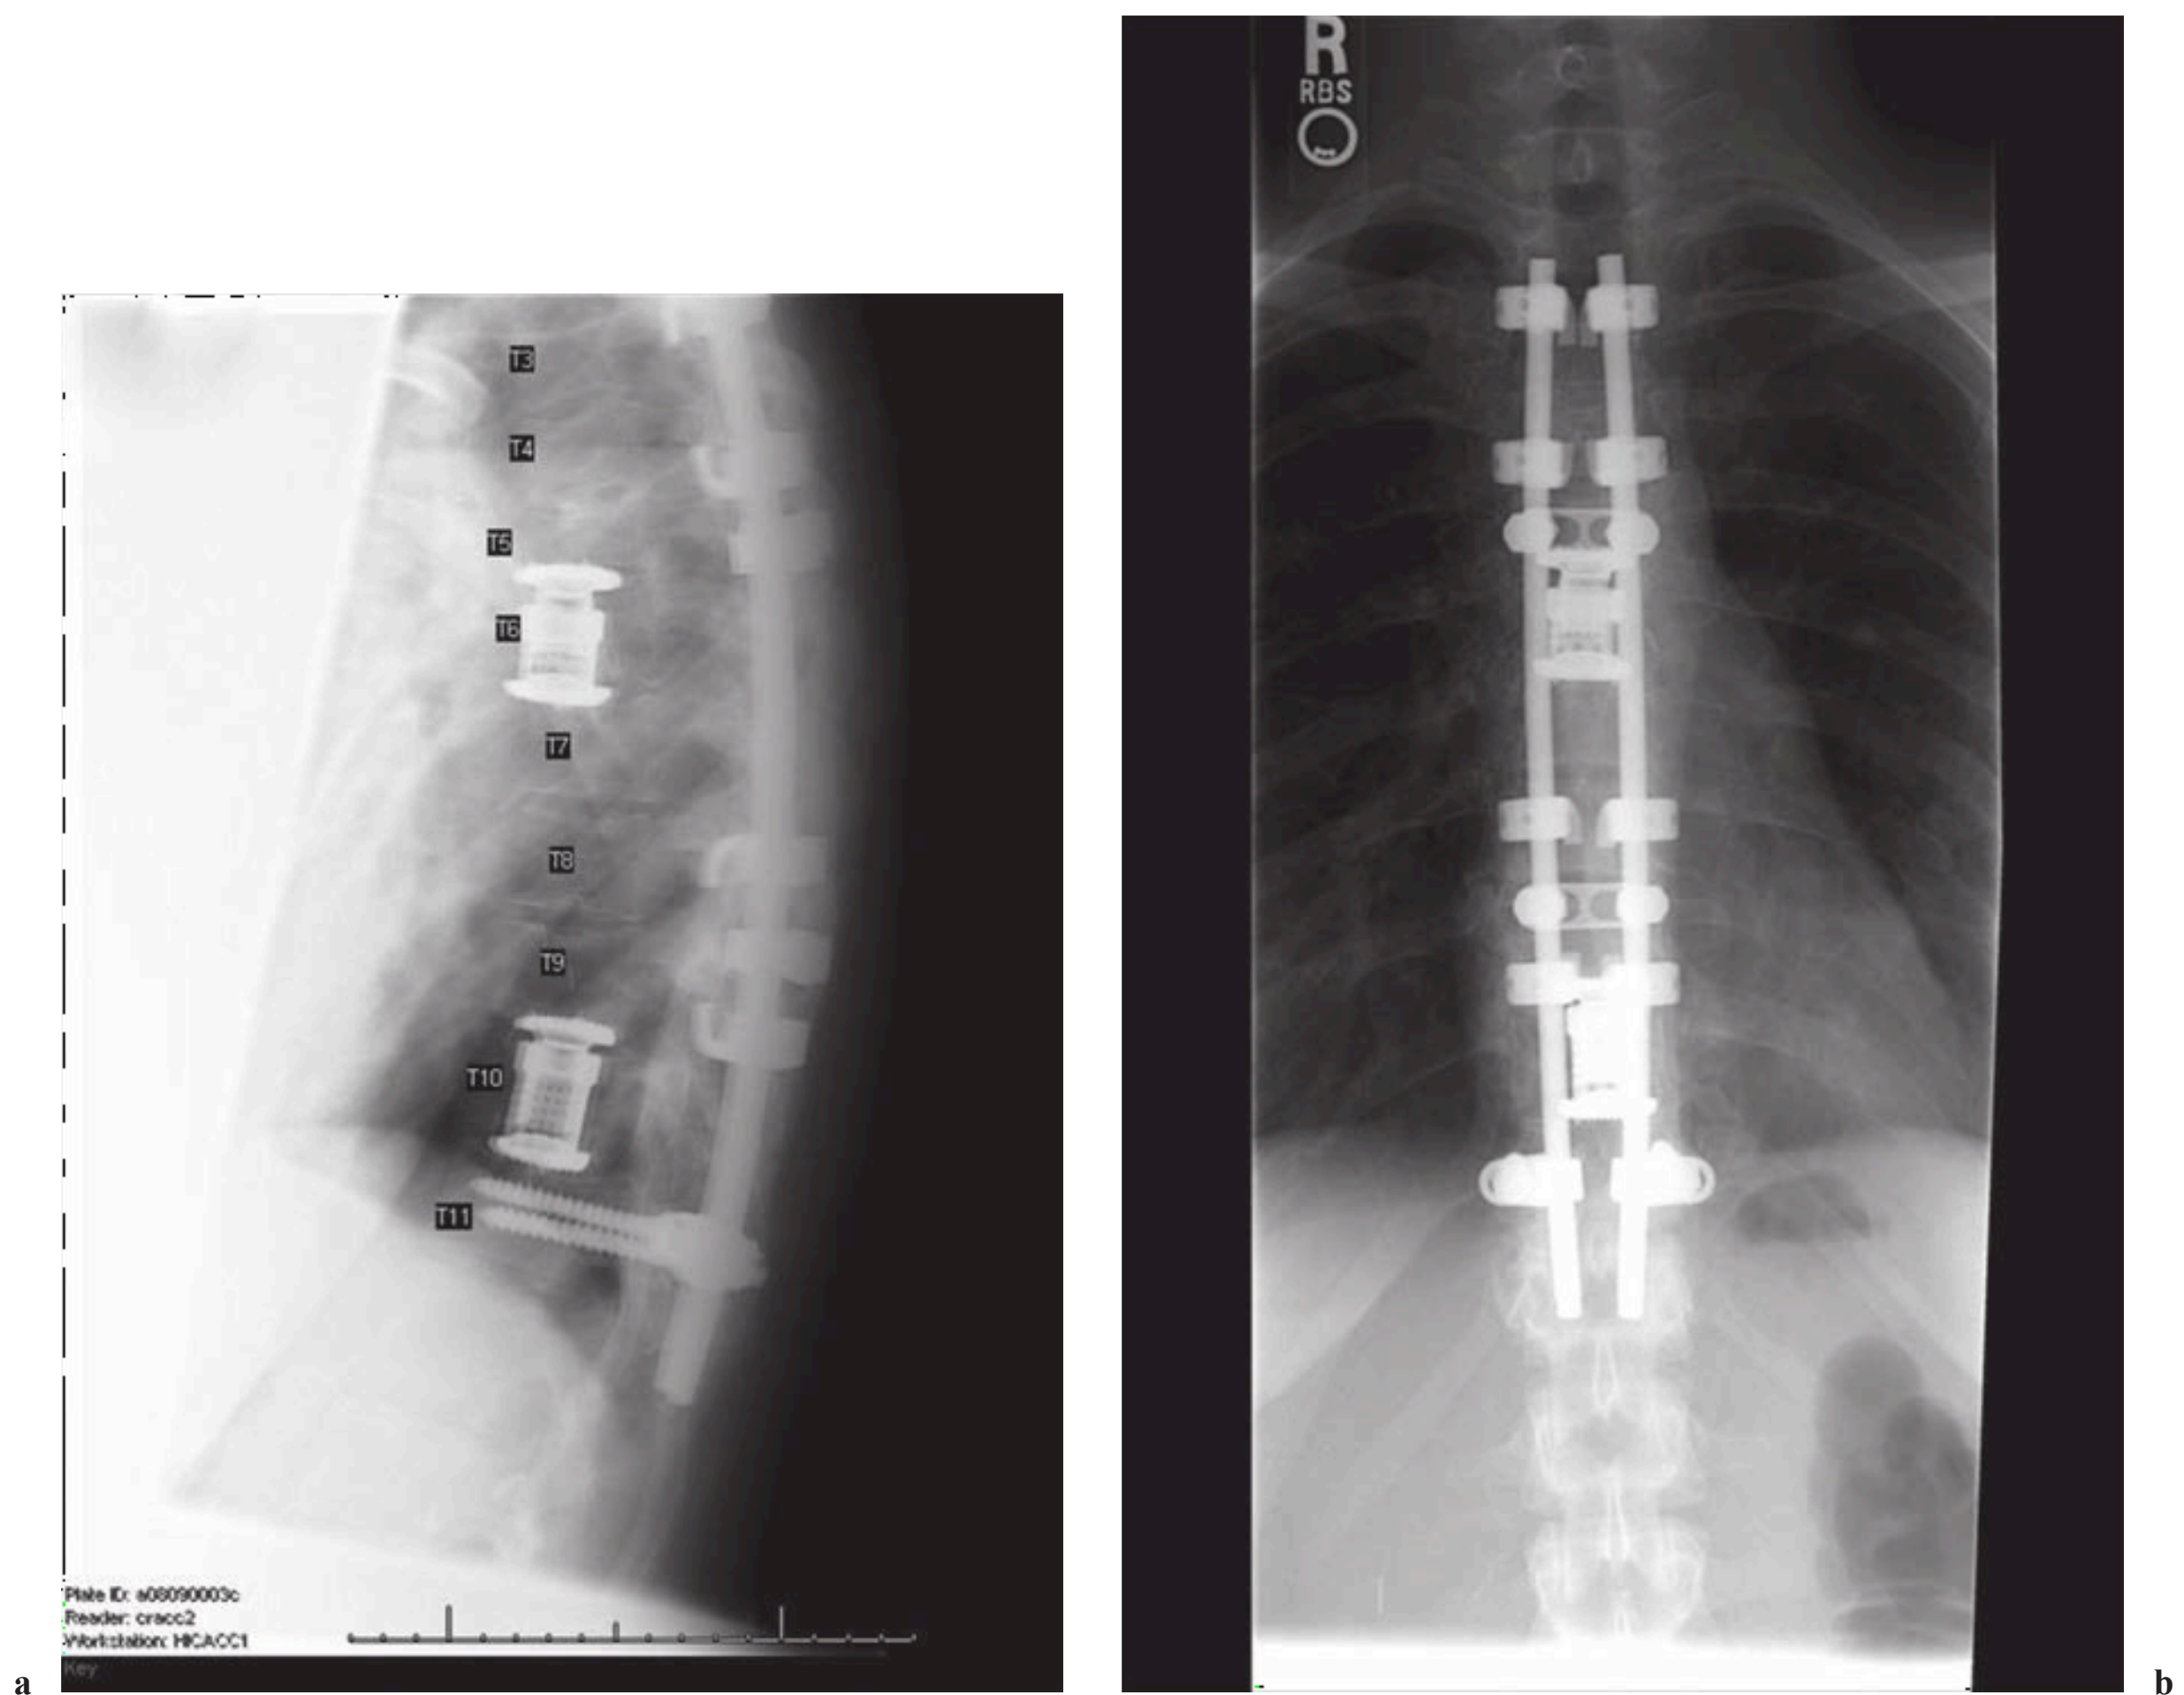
a, b (a) Lateral and (b) AP radiographs of open reduction procedure in patient depicted in Fig. 15.11. This procedure included anterior T6 and T10 corpectomies using two titanium cages packed with in situ autograft. Also performed were T5 laminectomy, T6-7 decompression laminotomies, and T3-T11 arthrodesis—instrumentation using sublaminar hooks, pedicle screws, rods, and cross links, supplemented with in situ autograft, demineralized bone matrix, and cancellous allografts.
